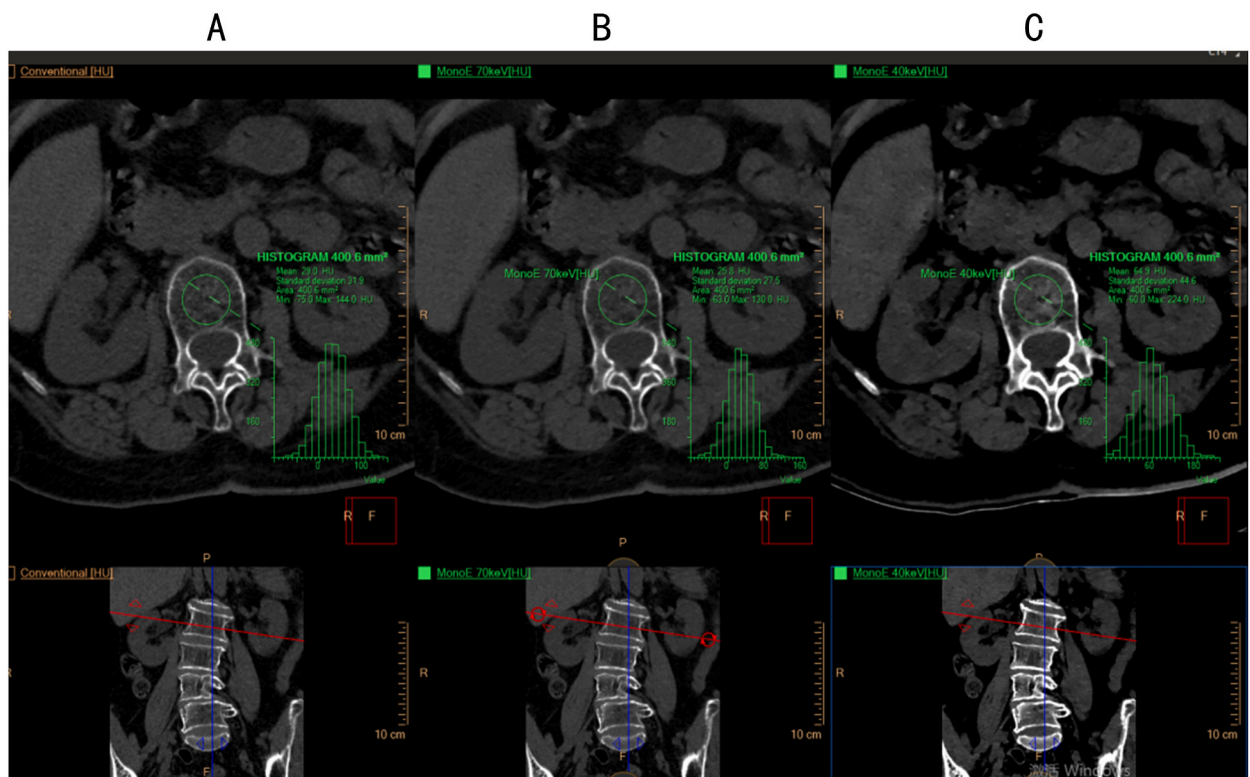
Virtual low energy IQon CT image. The CT values of the same vertebral body in the same patient under different (A) 120 kVp, (B) 70 keV and (C) 40 keV conditions. CT (120 kV) = 30Hu, CT (70 keV) = 26Hu, CT (40 keV) = 54.4Hu; CT (120 kV) and CT (70 keV) values are almost the same; CT (40 keV) > CT (120 kV).
